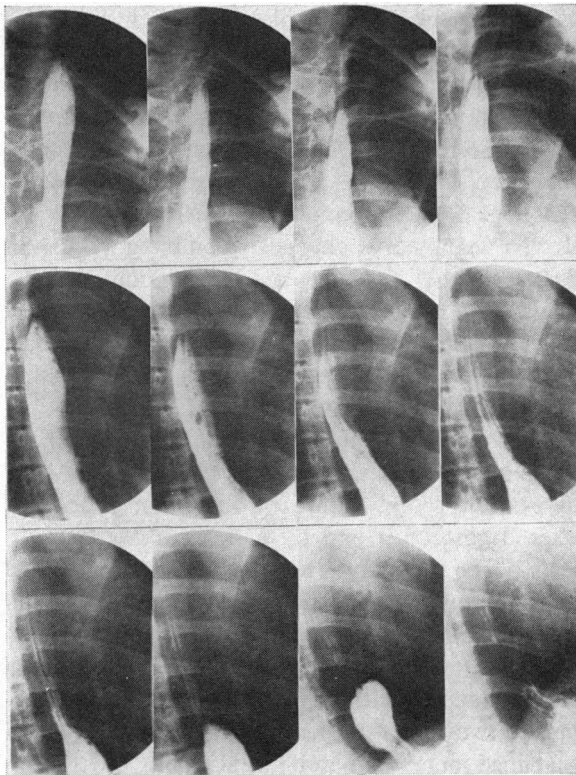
Roentgenographic appearance of normal peristalsis. With patient supine, serial 70 mm spot films were taken during a 4.5 second interval following deglutition of barium. The x-ray tube was shifted slightly caudal after frames 3 and 10. Peristalsis causes the tail of the barium column to assume an inverted V shape. The peristaltic wave is visualized as a progressive aboral movement of the inverted V through the esophagus. (Through the courtesy of W. B. Saunders Company, publishers, *Radiologic Clinics of North America* 7:147-161, April, 1969.)
